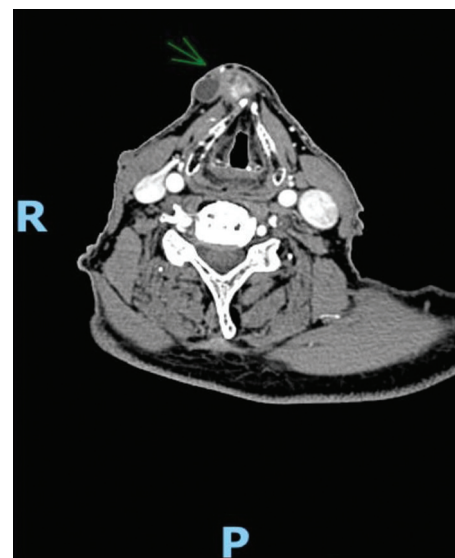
Axial computed tomography scan showing the thyroid gland with a right paramedian cystic component measuring 1.9 cm and a solid component with enhancement and internal calcifications measuring 1.7×1.7 cm, with fascia infiltration.
